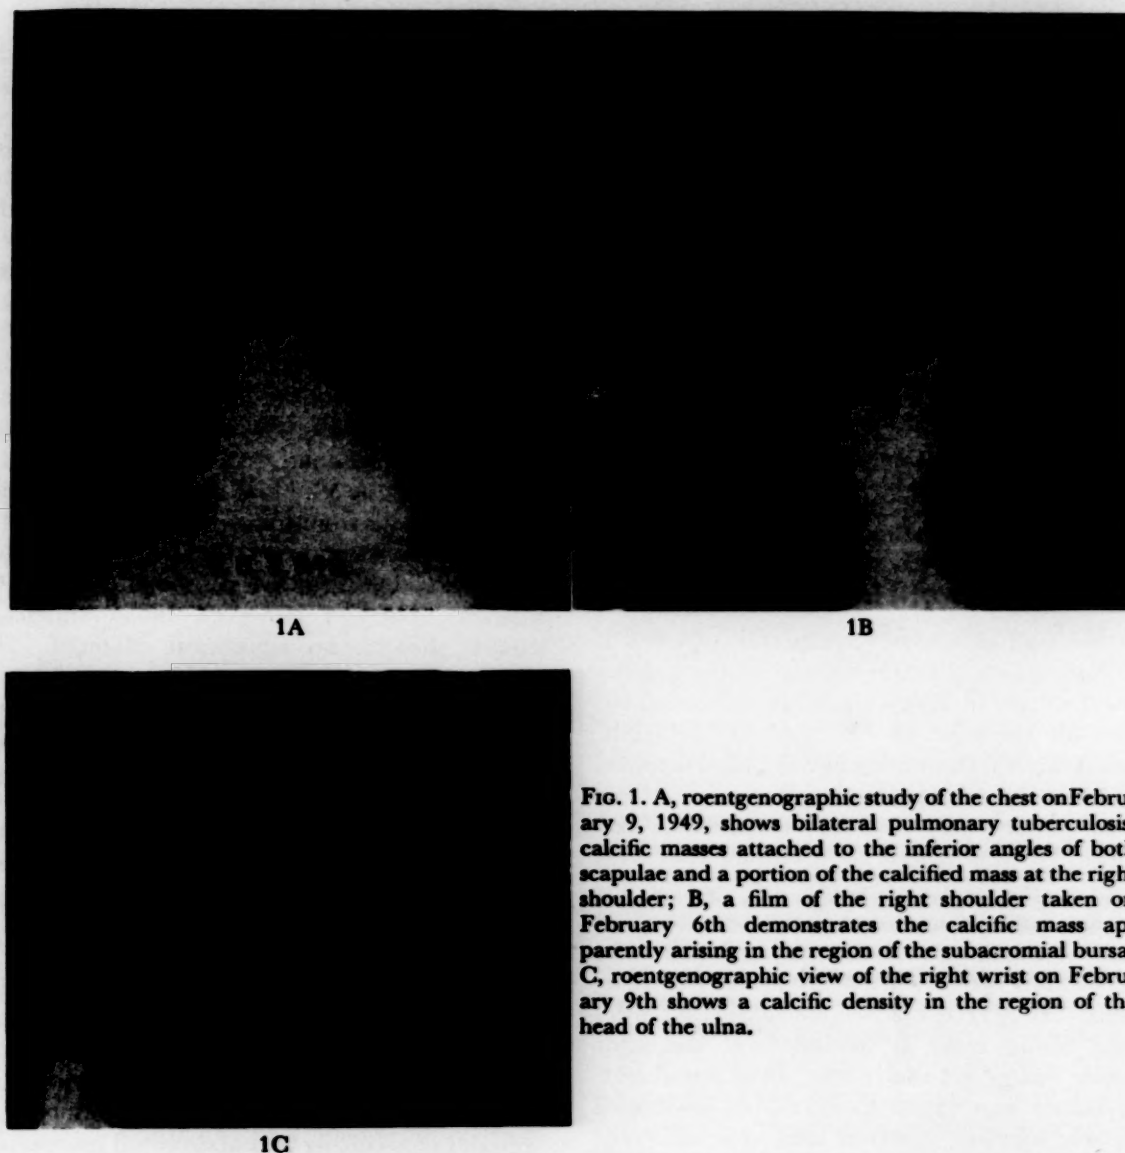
A, roentgenographic study of the chest on February 9, 1949, shows bilateral pulmonary tuberculosis, calcific masses attached to the inferior angles of both scapulae and a portion of the calcified mass at the right shoulder; B, a film of the right shoulder taken on February 6th demonstrates the calcific mass apparently arising in the region of the subacromial bursa; C, roentgenographic view of the right wrist on February 9th shows a calcific density in the region of the head of the ulna.
